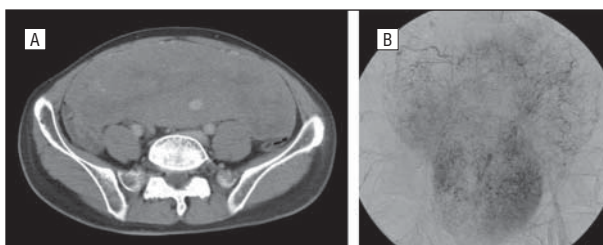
An abdominal computed tomographic scan showed a giant solid lesion occupying the entire abdominal cavity (A), and angiography showed a relatively hypervascular tumor in the entire abdomen (B).
